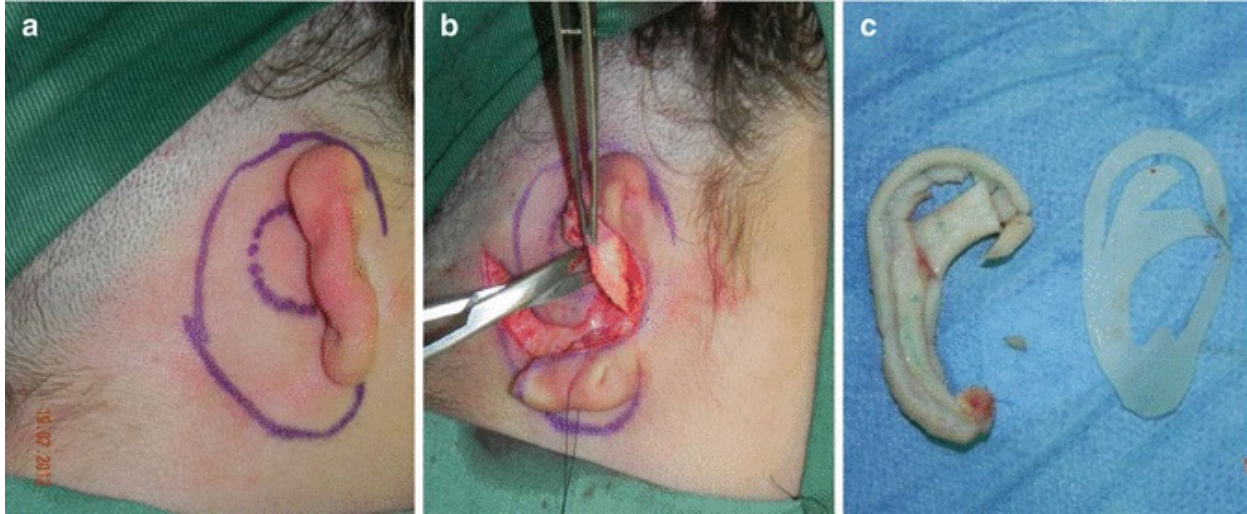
First stage of ear reconstruction on severe microtia during surgery. (a) Surgical planning and demarcation of spatial projection of the future ear; (b) the lobule is already rotated backward to its normal position and the remnant ear cartilage is being removed; (c) the new auricular framework is already sculpted by excavation according to the X-ray model
